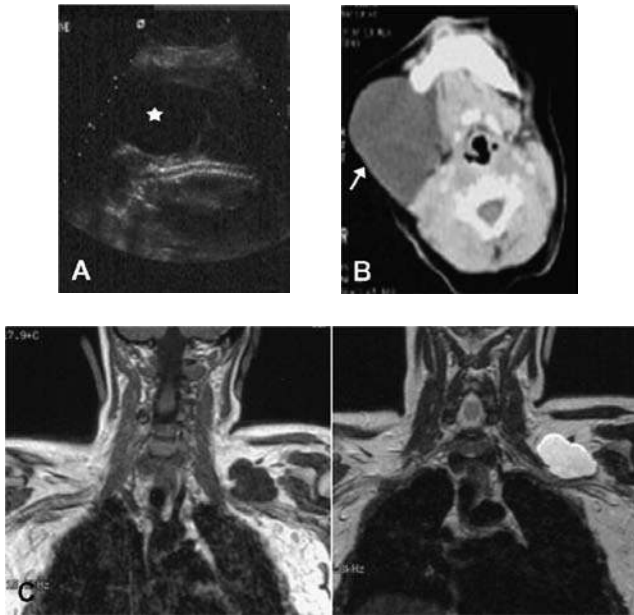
Three different lymphangiomas on sonography (A), CT (B), and MR images (C). Intrauterine sonography (A) shows a large anechoic neck mass (*) with septations that led to fetal demise. CT (B) reveals a low attenuation mass (arrow). MR images (C) demonstrate a low signal intensity mass (arrowheads) on T1-weighting (left image) and homogeneous high signal intensity on T2-weighting (right image). Abbreviations: CT, computerized tomography; MR, magnetic resonance.
